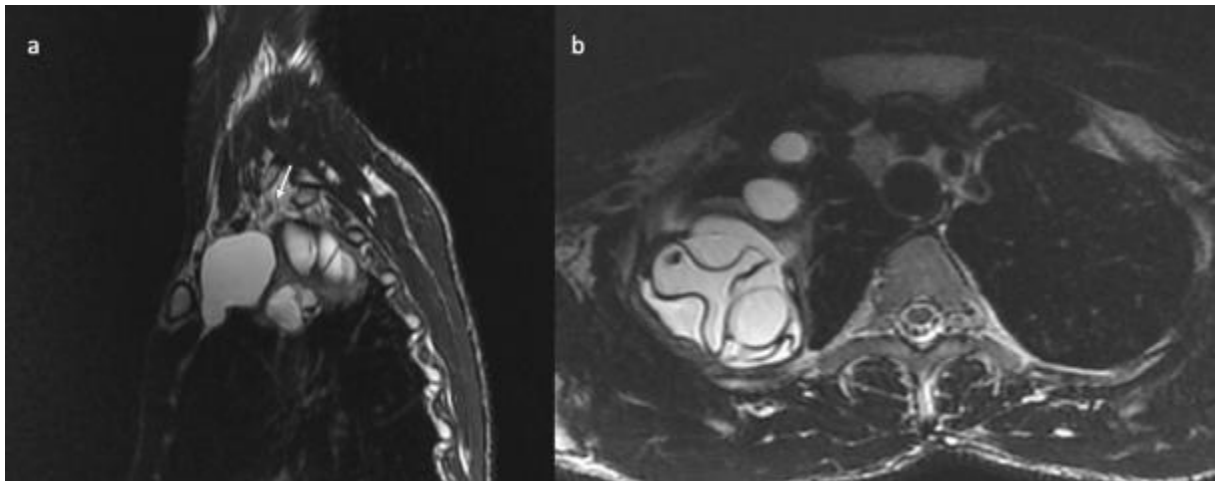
Sagittal (a) and axial (b) MRI T2 weighted images revealing a large cystic mass of the right pulmonary apex which is hyperintense on T2 weighted images and delineated by a hypointense rim and containing hypointense membranes. There was also a compression of the axillary nerve (white arrow)
